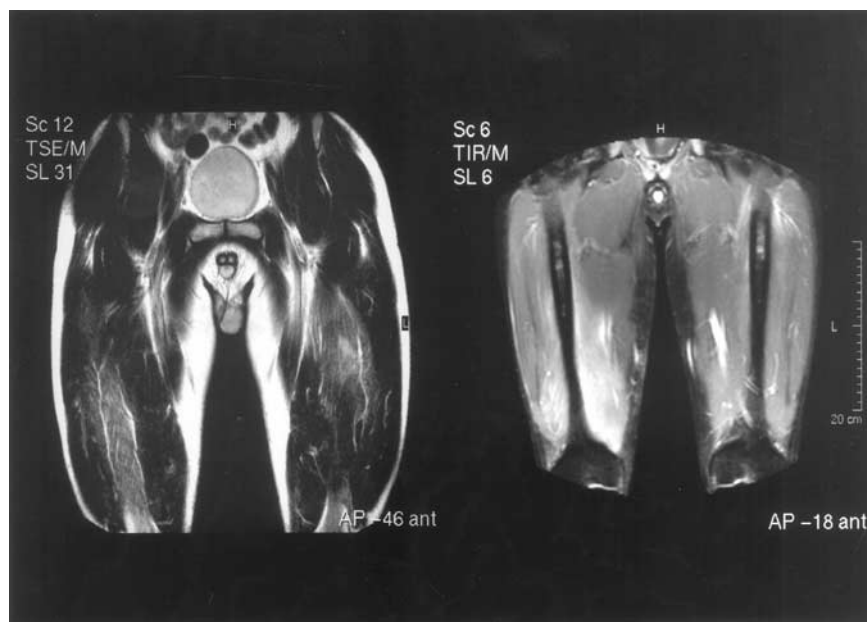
MRI of both thighs revealed abnormal hypersignal intensity of M. quadriceps femoris on T2-weighted (left) and STIR images (right).
